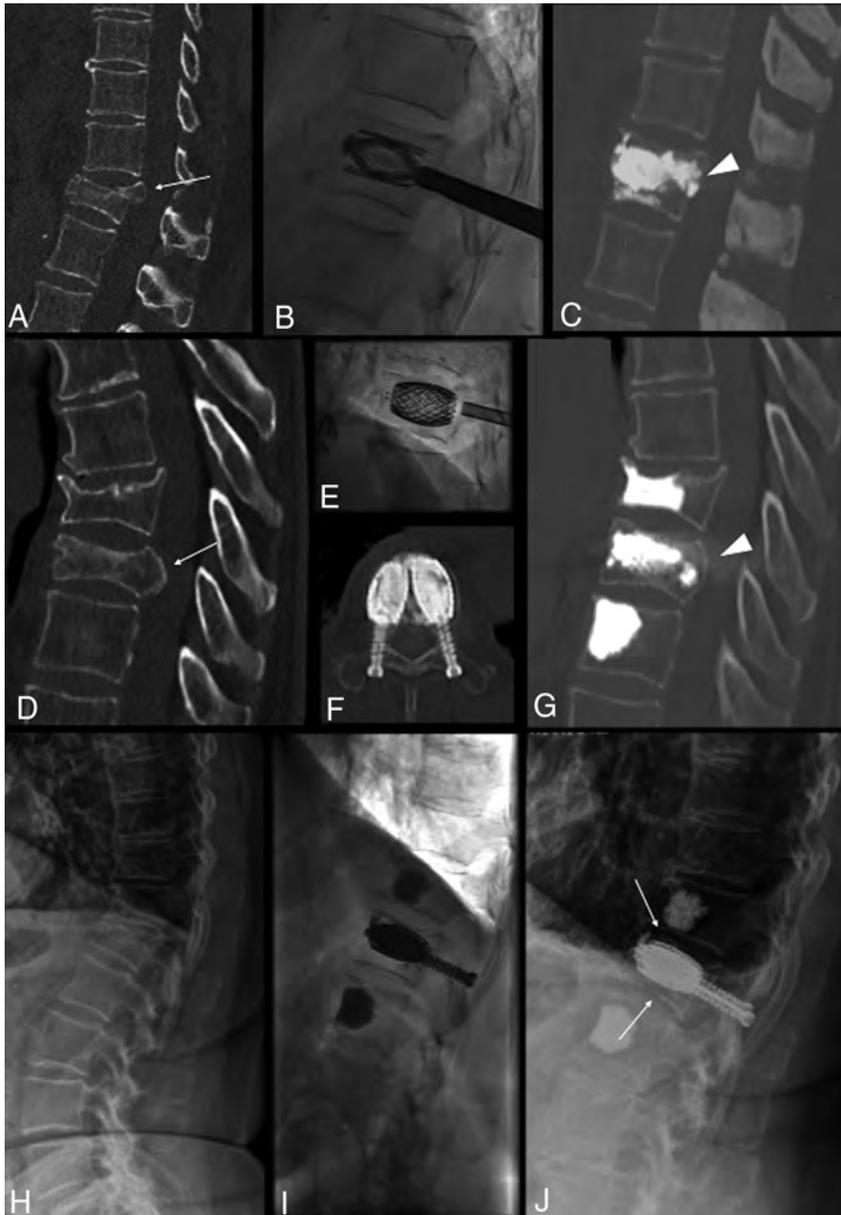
Three different cases (A–C), (D–G), and (H–J). A–C, Treatment with the SpineJack of a traumatic incomplete burst fracture of T12 in a 55-year-old man with posterior wall retropulsion (arrow, A) and junctional kyphosis. Postoperative CT shows vertebral height restoration, central canal clearance through retropulsed fragment correction (arrowhead, C), and kyphosis correction. D–G, Treatment with the SAIF technique of a traumatic T10 fracture in a 78-year-old man with osteoporosis with >50% height loss and posterior wall retropulsion (arrow, D), with effective height restoration and posterior wall reposition (arrowhead, G). H–J, Treatment of an L1 osteoporotic fracture with bone subsidence (arrows, J) around the cement cast at 1-month follow-up, not compromising alignment and curvature. The patient was asymptomatic.
